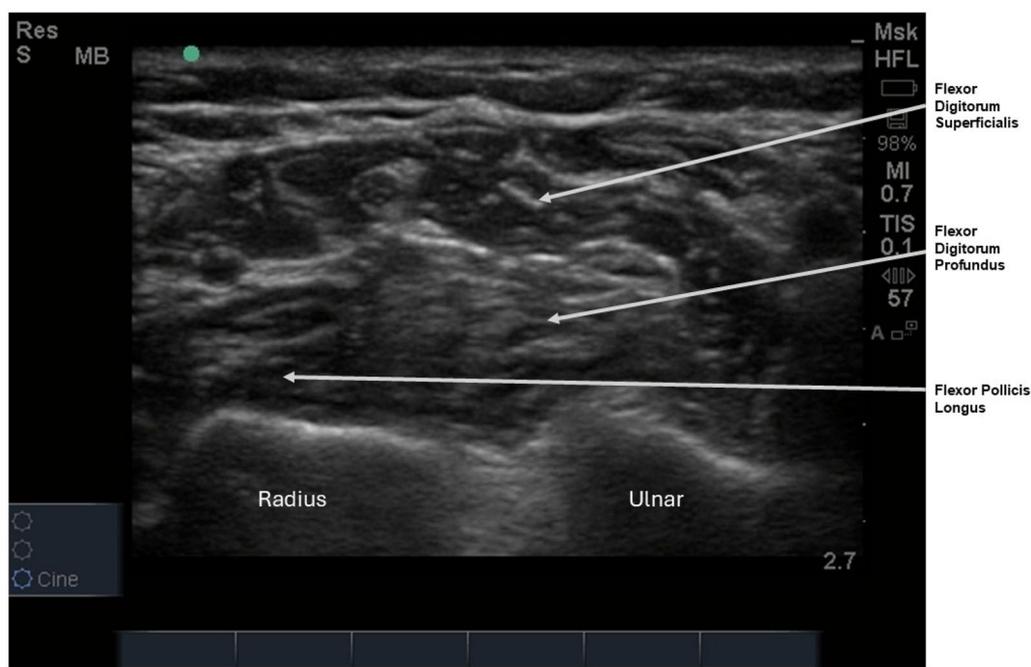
A cross-sectional ultrasound image of the mid forearm flexor compartment. The radius and the ulnar can be seen at the bottom of the image. Above them is the flexor digitorum profundus and beside it to the left flexor pollicis longus. More superficial can be seen in the flexor digitorum superficialis. The vessels and medial nerve can also be seen (medial nerve is central to the right of the image).
